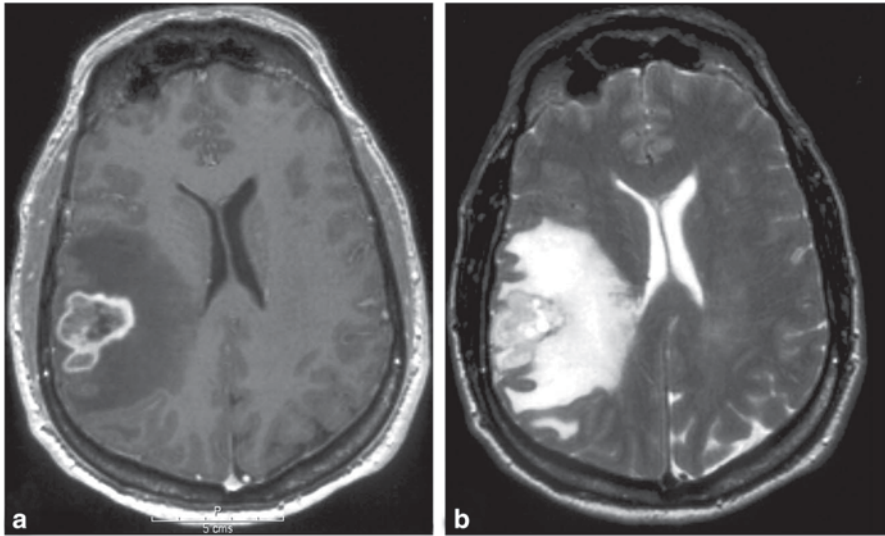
Magnetic resonance imaging of a patient with malignant glioma. a Axial T_1 -weighted image reveals water-containing tissue as hypo-intense. Central hypo-intense area is consistent with necrosis. b T_2 -weighted MRI from the same patient allows water-containing tissue to be seen as hyper-intense. This signal is consistent with vasogenic edema. (Reproduced with permission from Pope 2005. Copyright American Society of Neuroradiology)
